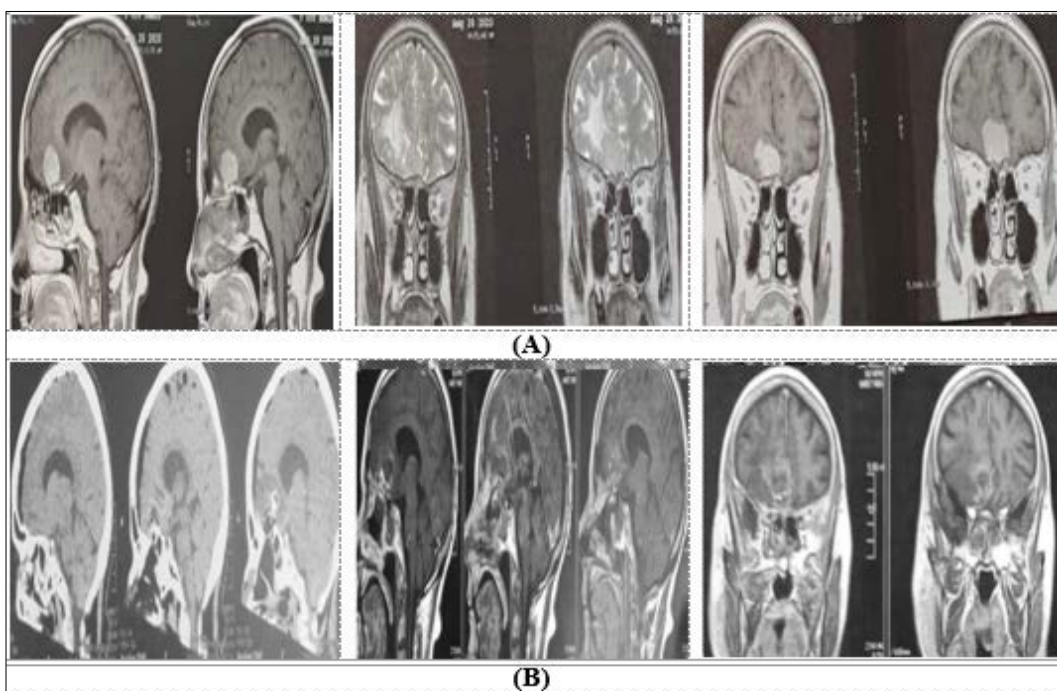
Contrast-enhanced magnetic resonance imaging brain and computed tomography of olfactory groove meningioma (A) Pre-operative and (B) Post-operative
